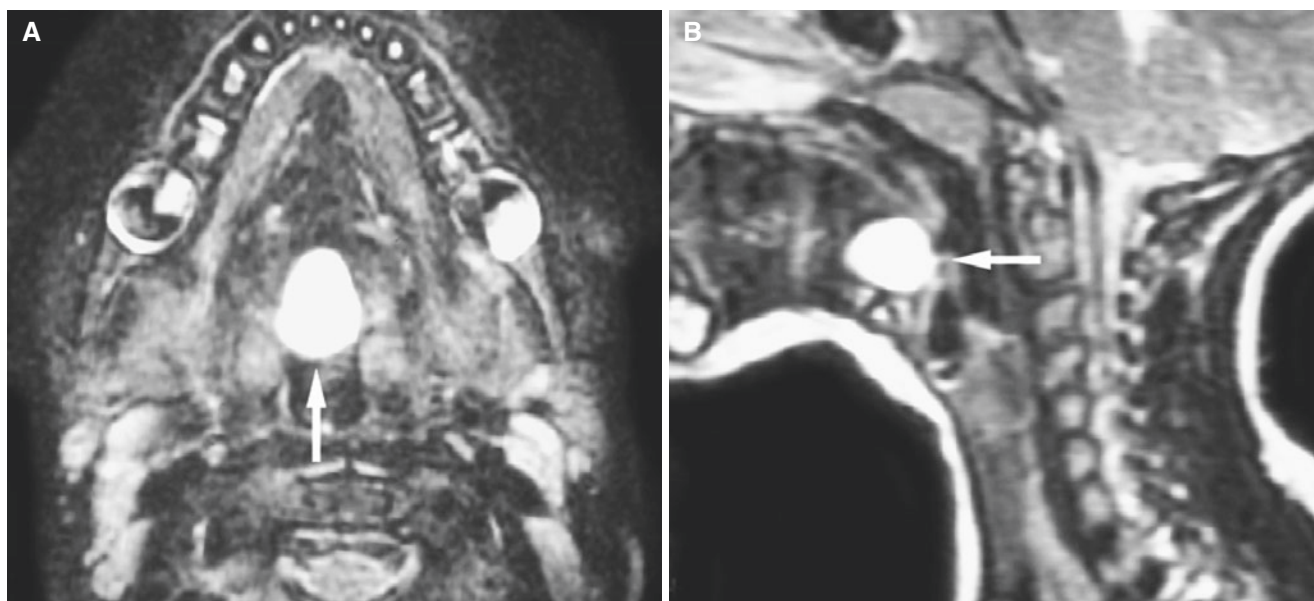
Thyroglossal duct cyst; 3-year-old female with mass in the midline of the base of the tongue. (A) Axial T2-weighted MRI shows well-defined high-signal mass in the base of the tongue (*arrow*). (B) Sagittal T2-weighted MRI confirms high-signal mass in the tongue (*arrow*)
